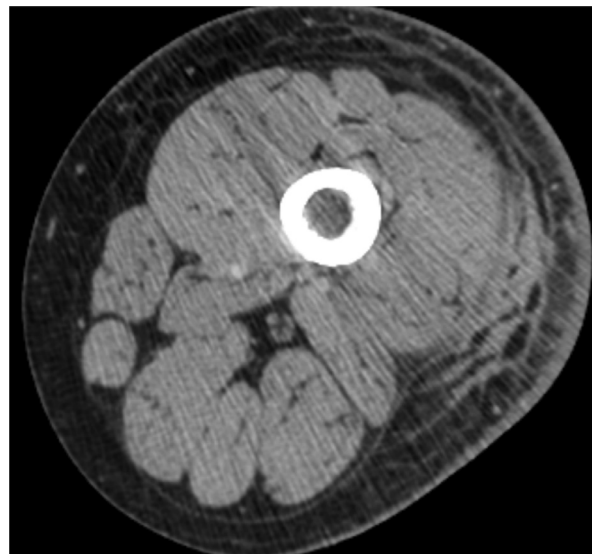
Axial CT image, in soft tissue windows, of the distal left thigh following the administration of intravenous contrast reveals the area of induration, skin thickening, and mild subcutaneous edema with mild inflammatory stranding. No definite enhancement.
